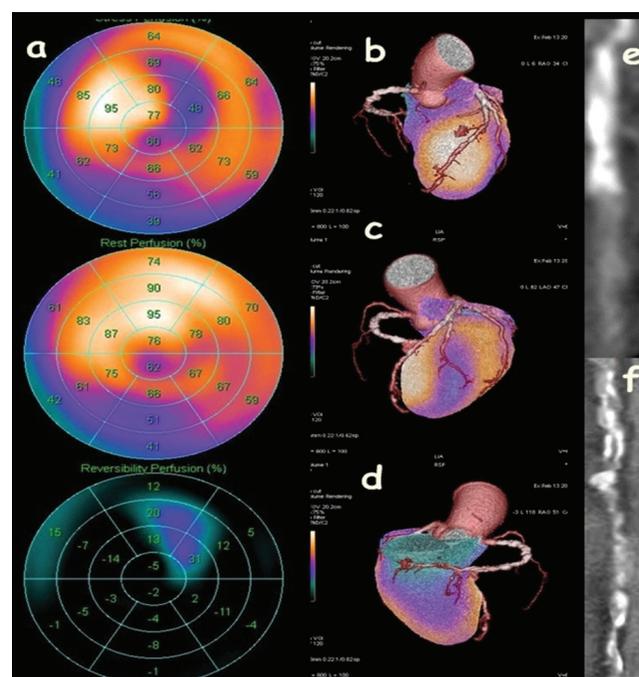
gMPS and CHI findings a) gMPS polar map images; top: Stress perfusion, medium: Rest perfusion, bottom: Reversibility perfusion. b) Fusion image; normal perfusion areas at LAD vascularization zone. c) Fusion image; reversible perfusion defects at diagonal artery vascularization zone. d) Fusion image; fixed perfusion defects at RCA vascularization zone. e) CCTA image; severe calcified stenosis at diagonal artery. f) CCTA image; severe calcified stenosis at main body of RCA. gMPS: Gated myocard perfusion scintigraphy, CHI: Cardiac hybrid imaging, LAD: Left anterior descending artery, RCA: Right coronary artery, CCTA: Coronary computed tomography angiography
